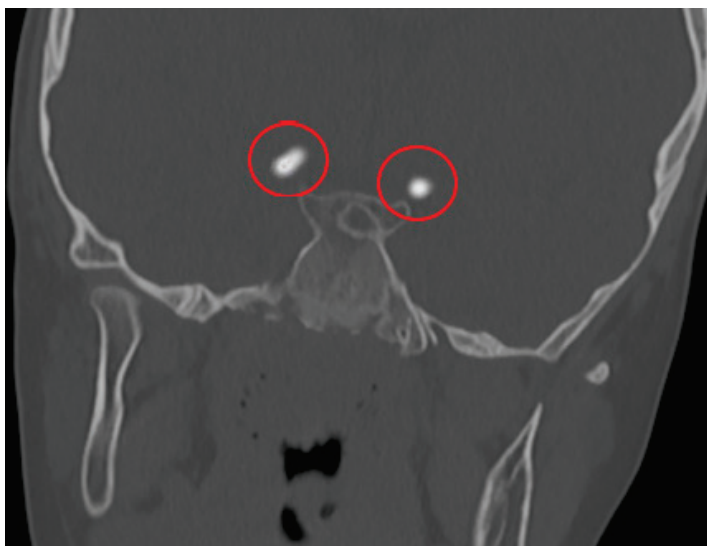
A 9-year-old male patient complained of severe headache and nausea and vomiting. Cranial CT imaging was performed. Hyperdense punctate calcification is shown in the V4 segment of the bilateral vertebral artery (circles).
